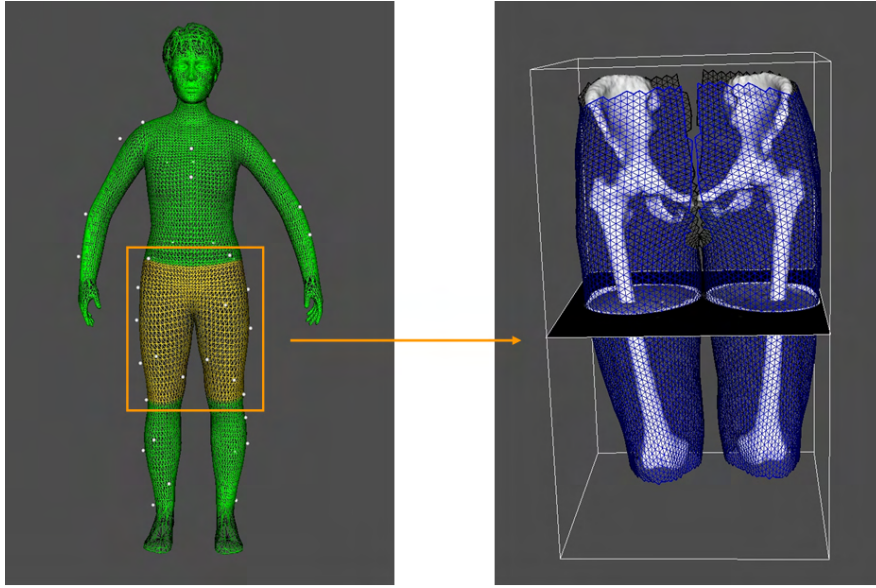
The markers and the body scan model segmented into two parts (left): the yellow part is conformed to the MRI skin model (right) and the green parts are rigidly registered.
